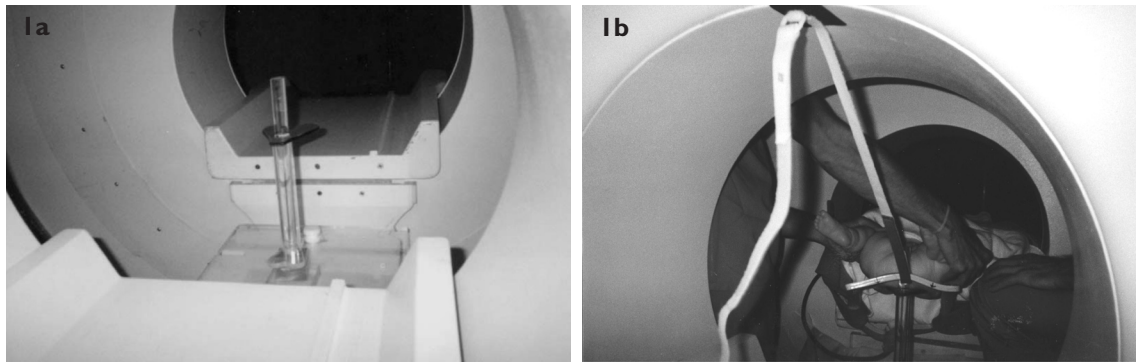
Set-up of the hip spica table and positioning of the baby within the open MR imaging unit. (a) Photograph of the custom-built, plastic hip spica table placed in the centre of the double doughnut-shaped open MR imaging unit. The spica table is composed of a horizontal base plate, a round vertical pole and a small horizontal plate. The base plate is fitted on the connecting bar between the two doughnut rings of the magnet. On this base, the vertical pole is constructed bearing a small horizontal teardrop-shaped plate to support the baby's buttocks. The latter plate is available in several sizes adjustable to the patient and at the same horizontal level as the patient table proper of the MR imaging unit. (b) Photograph shows that the baby's upper body (shoulder blades and head) is placed on the MR patient table proper, which is only partially moved towards the centre of the magnet while the buttocks rest on the teardrop-shaped plate in the centre of the magnet. Note the easy access to the baby for two physicians performing the Ortolani manoeuvre in an attempt to reduce the dislocated hip. The quadrangular, flexible surface coil is positioned immediately below the baby's hips using Velcro strips attached to the magnet, and not interfering with the clinical stress testing. During casting, straps had to be detached to lower the coil and allow for circumferential casting of the pelvis and abdomen. Intermittently, the straps are reattached to reposition the coil close to the baby's hips for imaging during casting.
